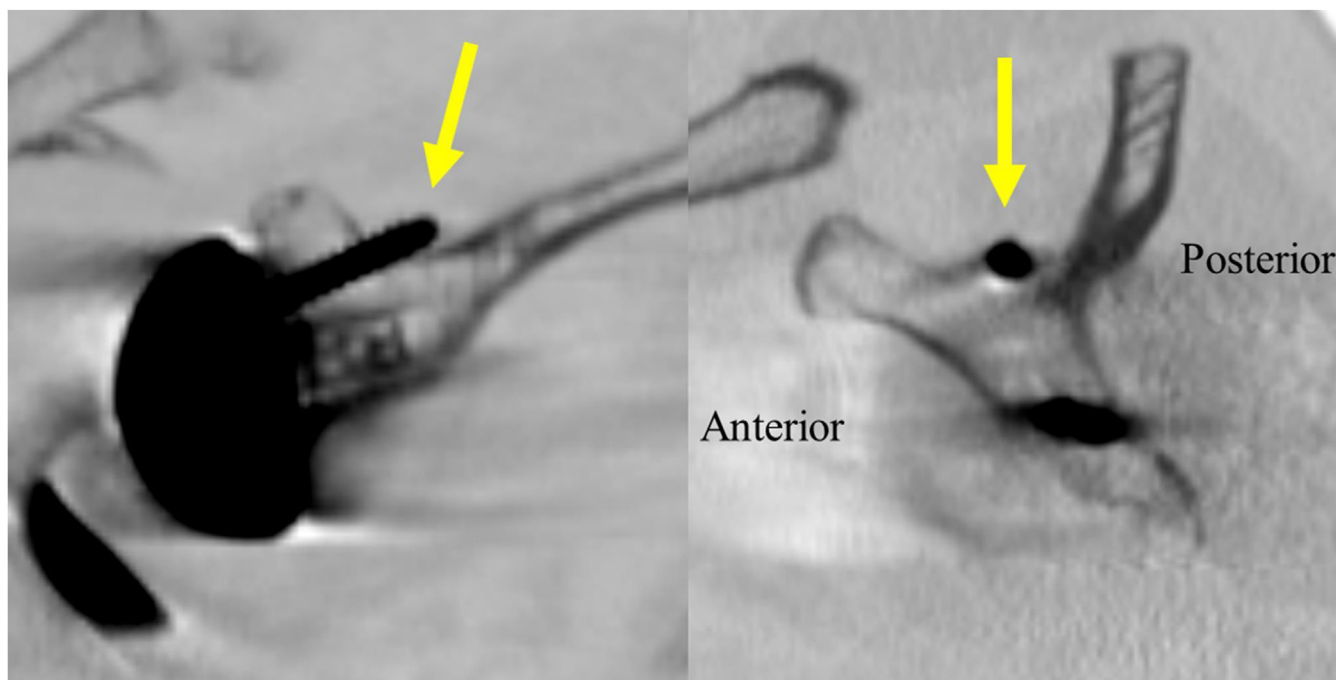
Penetration of superior screw into the suprascapular fossa in the oblique coronal and oblique sagittal CT view, two months postoperatively. (→) indicates the penetration of superior screw into the suprascapular fossa. CT, computed tomography.
